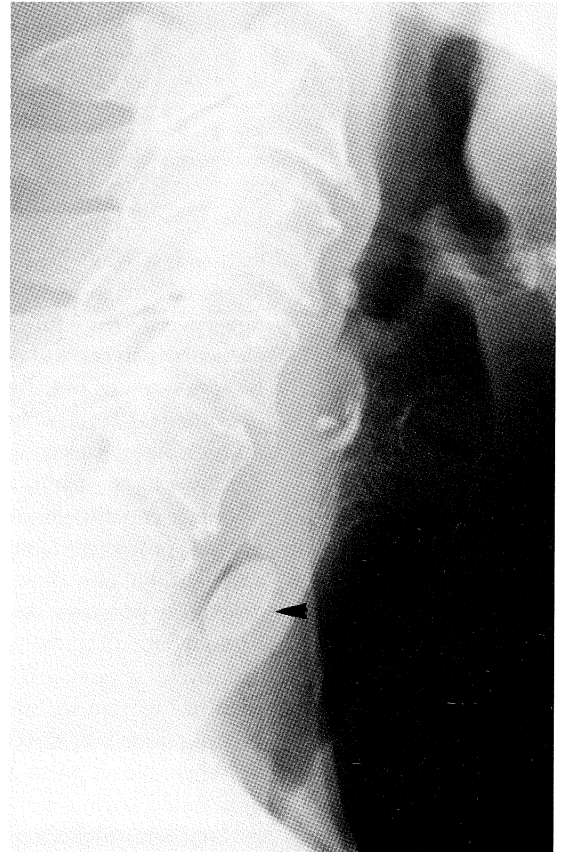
Lateral cervical X-ray showing foreign body in cervical oesophagus
